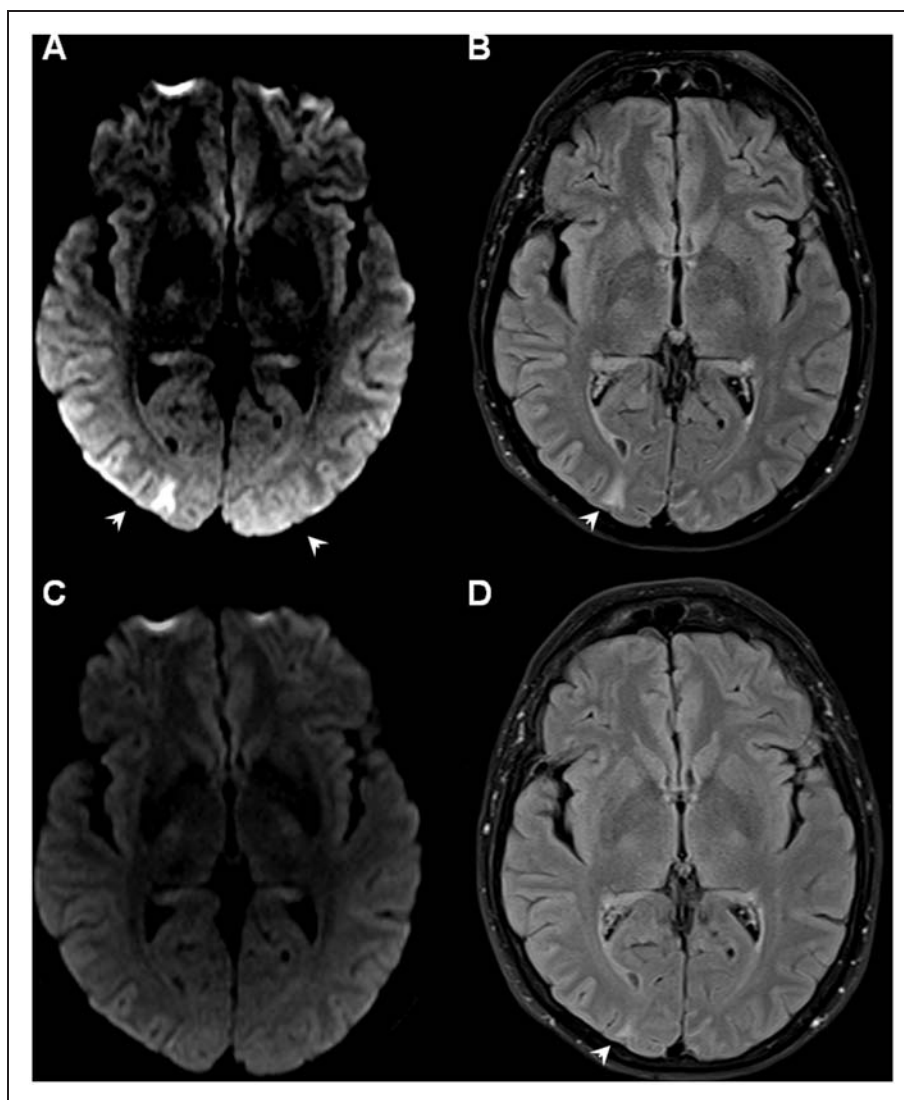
Diffusion-weighted (DWI) MRI (A) and fluid attenuated inversion recovery (FLAIR) (B), revealing hyperintensities in both occipital lobes, with a right occipital lesion consistent with ischemic stroke (arrows). MRI performed 3 months later showing no abnormalities in DWI (C) and a marked improvement in the hyperintense right occipital lesion in FLAIR (arrow, D).
